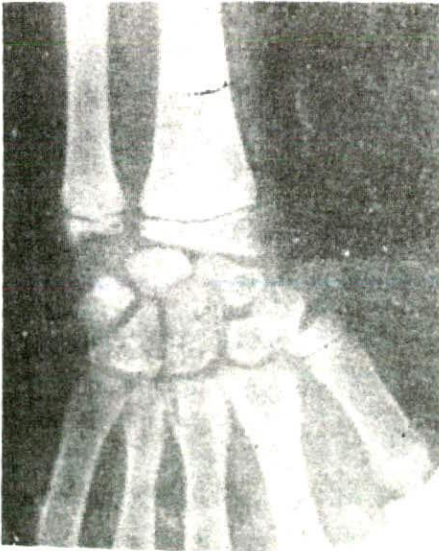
X-ray photograph of the wrist and hand. All the carpal bones are seen. The lower epiphyses of first metacarpal not united with the shaft.
